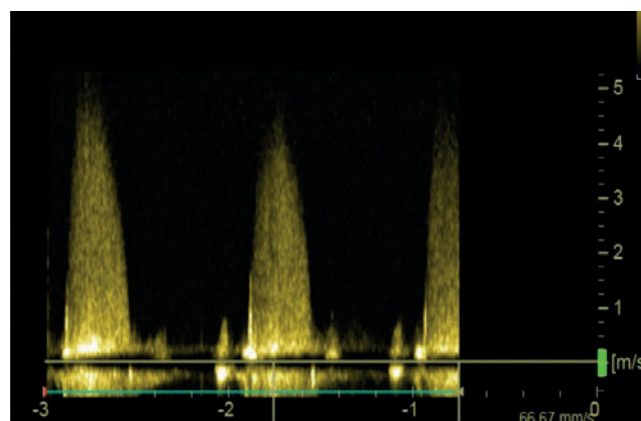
PEDOF from the right parasternal edge (RSE). GE Doppler P2D probe on Vivid S70 machine.
